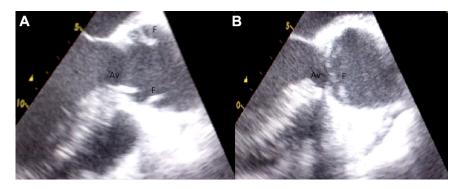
Transesophageal echocardiogram during (A) systole and (B) diastole showing ascending aorta, aortic valve and proximal intimal flap. (Av = aortic valve; F = proximal intimal flap.)
